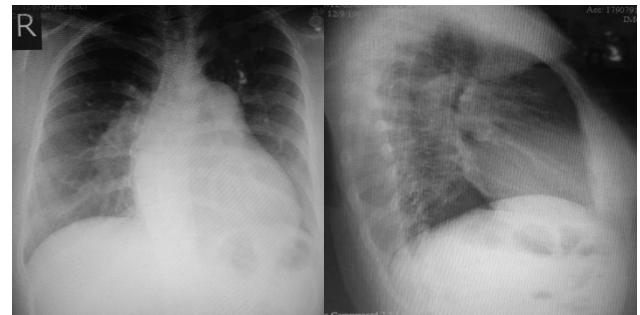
Chest X-ray a. PA view b. lateral view showing slight increased pulmonary vascularity, prominent main pulmonary artery, rounding of the apex and retrosternal fullness and rightward deviation of the thoracic spine
